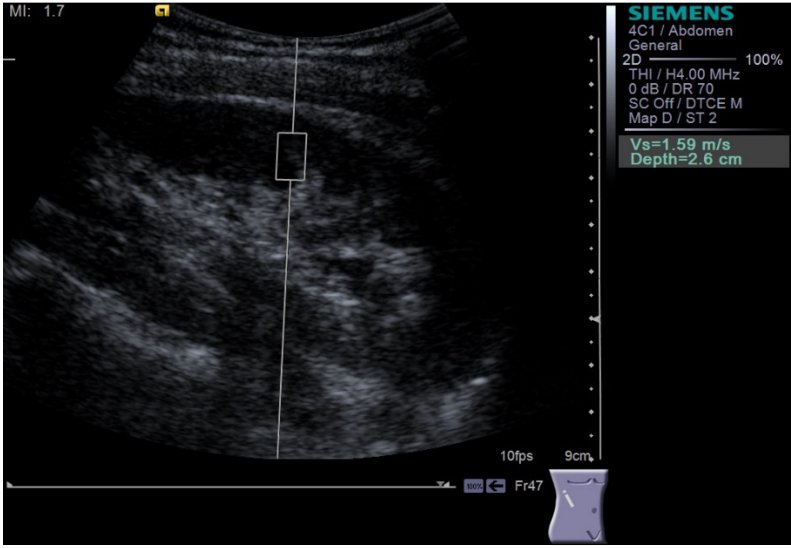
Shear wave speed (expressed in m/s) measured using the pSWE method: Virtual Touch™ Tissue Quantification (VTQ), software version 2.0, on an ultrasound system Siemens Acuson S2000™ (Siemens AG, Erlangen, Germany) with 4C1 transducer.
